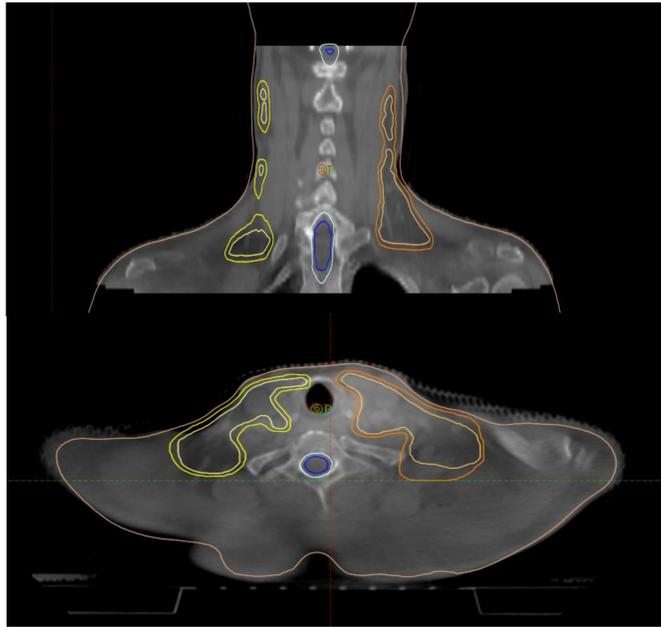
Shoulder gap measurement using CBCT
